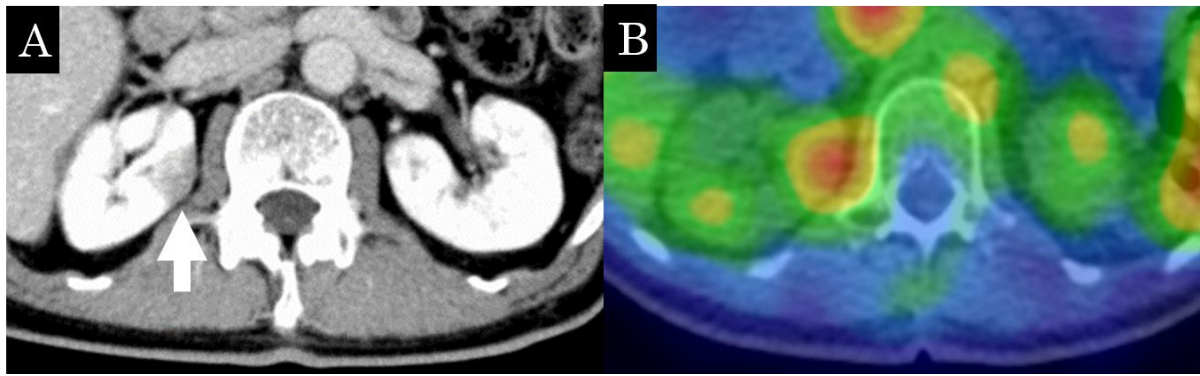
The wedge-shaped low density area is seen on contrast-enhanced CT (A, arrow), suggesting interstitial nephritis. A ^{67}Ga SPECT/CT shows a high accumulation in the corresponding area (B).
